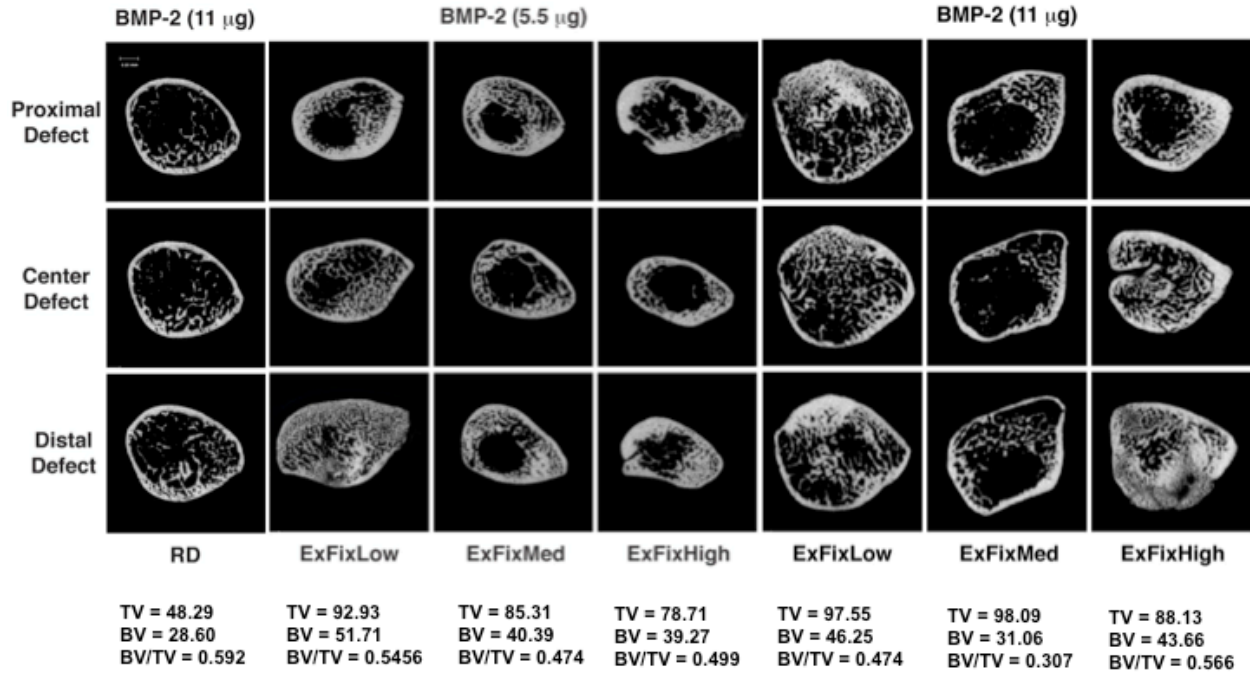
Cross sectional μ CT images after 8 weeks of healing with 11 μ g or 5.5 μ g BMP-2 under conditions of low (ExFixLow), medium (ExFixMed) or high (ExFixHigh) stiffness fixation or reverse dynamization (RD)
